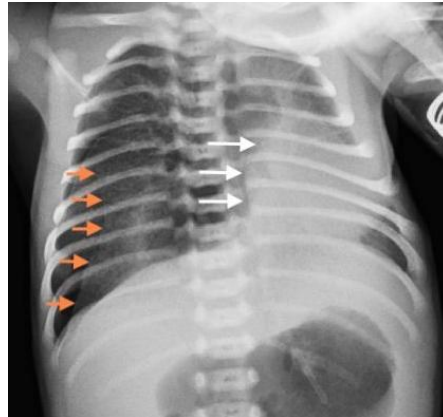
Anteroposterior projection of thorax x-ray pre-chest intercostal drainage
